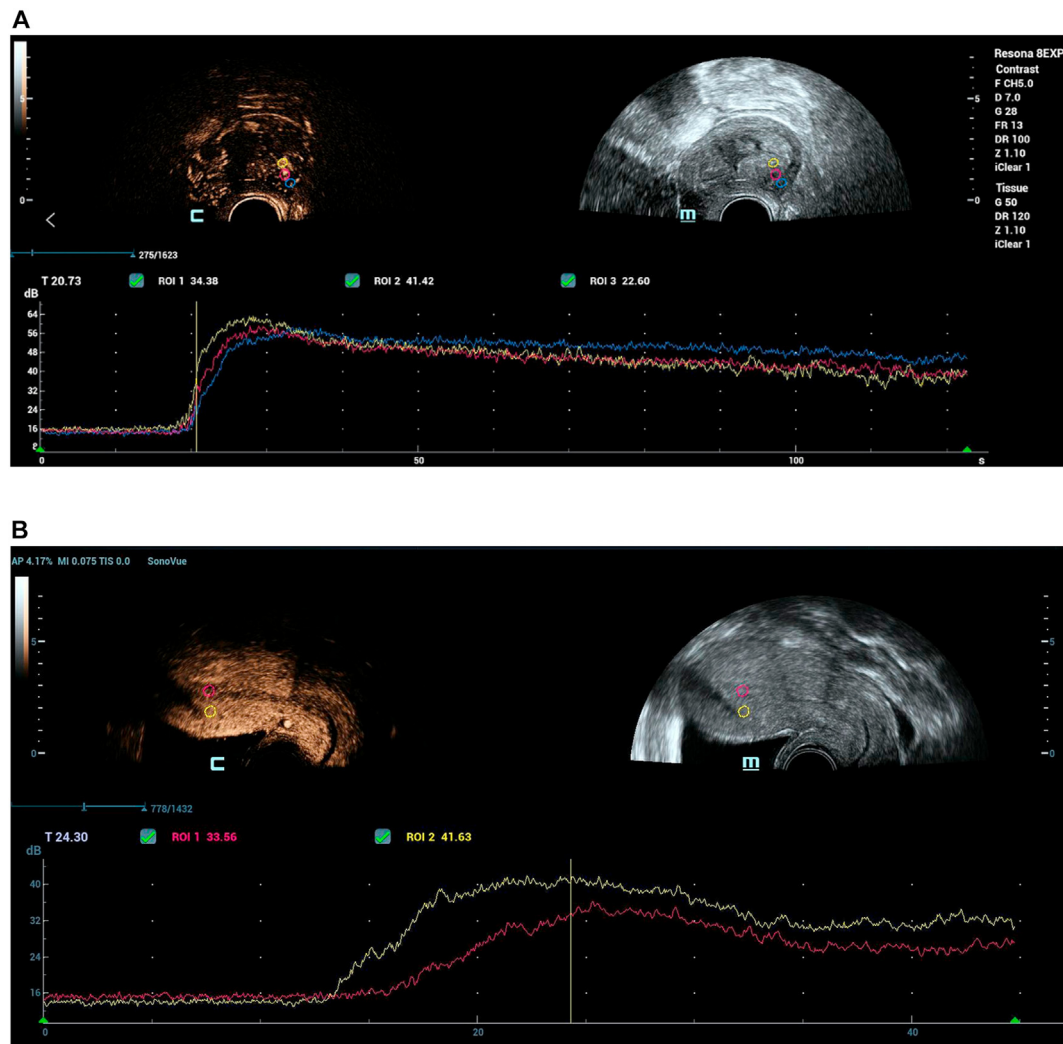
Time-intensity curves derived from contrast-enhanced ultrasonography. Fig. 1A Time-intensity curves derived from contrast-enhanced ultrasonography of the region where there is an endometrial invasion. (Yellow: endometrial carcinoma lesion, pink: invaded myometrium, blue: normal myometrium). Fig. 1B Time-intensity curves derived from contrast-enhanced ultrasonography of regions with no endometrial invasions. (Pink: normal endometrium, yellow: normal myometrium).
